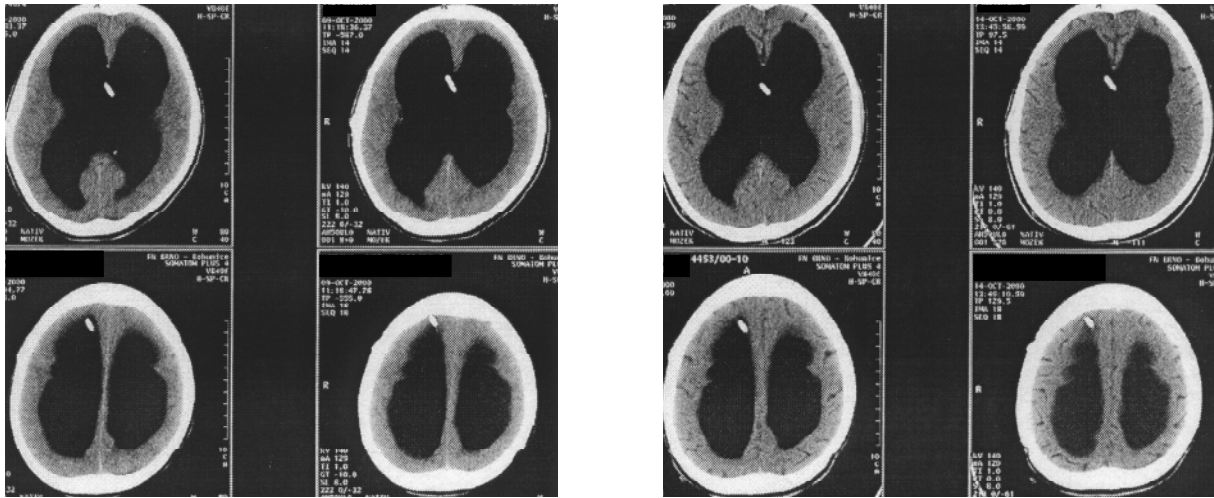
Decompensated hydrocephalus in admission (left), improvement of the CT finding before discharge with apparent gyration (right).
